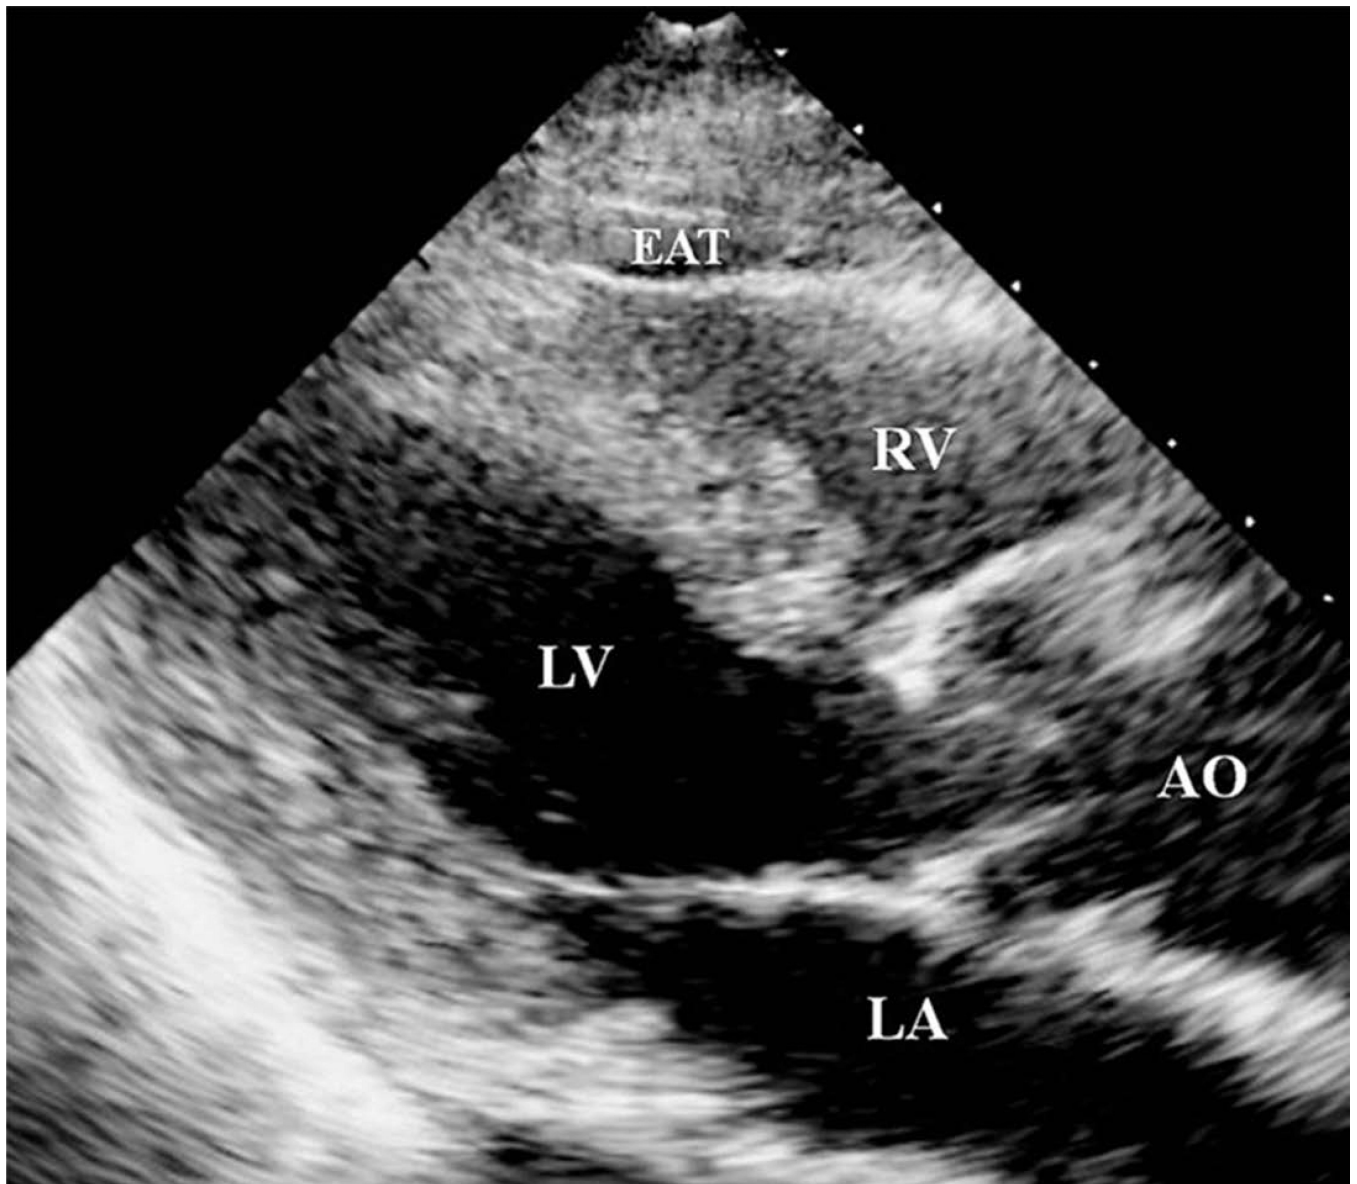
Measurement of epicardial adipose tissue measured in parasternal long-axis view of TTE. AO = aorta; EAT = epicardial adipose tissue; LA = left atrium; LV = left ventricle; RV = right ventricle. (Reproduced from ref 15)
